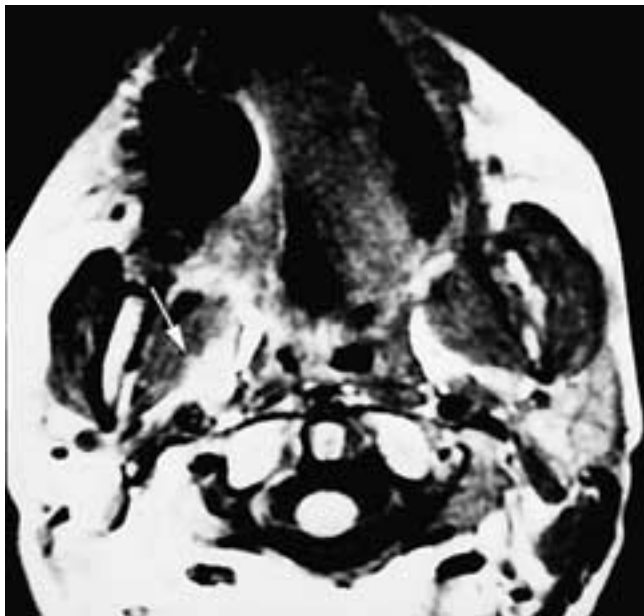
Axial T1-weighted MR image shows slightly increased fat in the right parapharyngeal space. The feature differentiating a benign lipoma (see Fig. 38-28) from this liposarcoma is the infiltration of the right medial pterygoid muscle (*arrow*).
